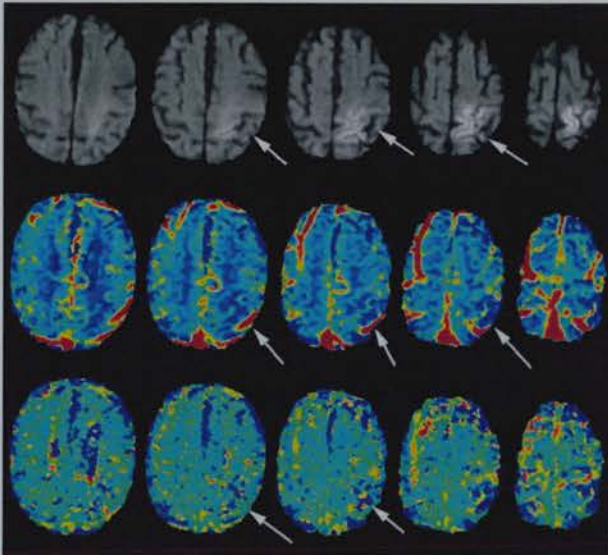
A patient with a small mismatch (PI around 20% greater than DWI)
